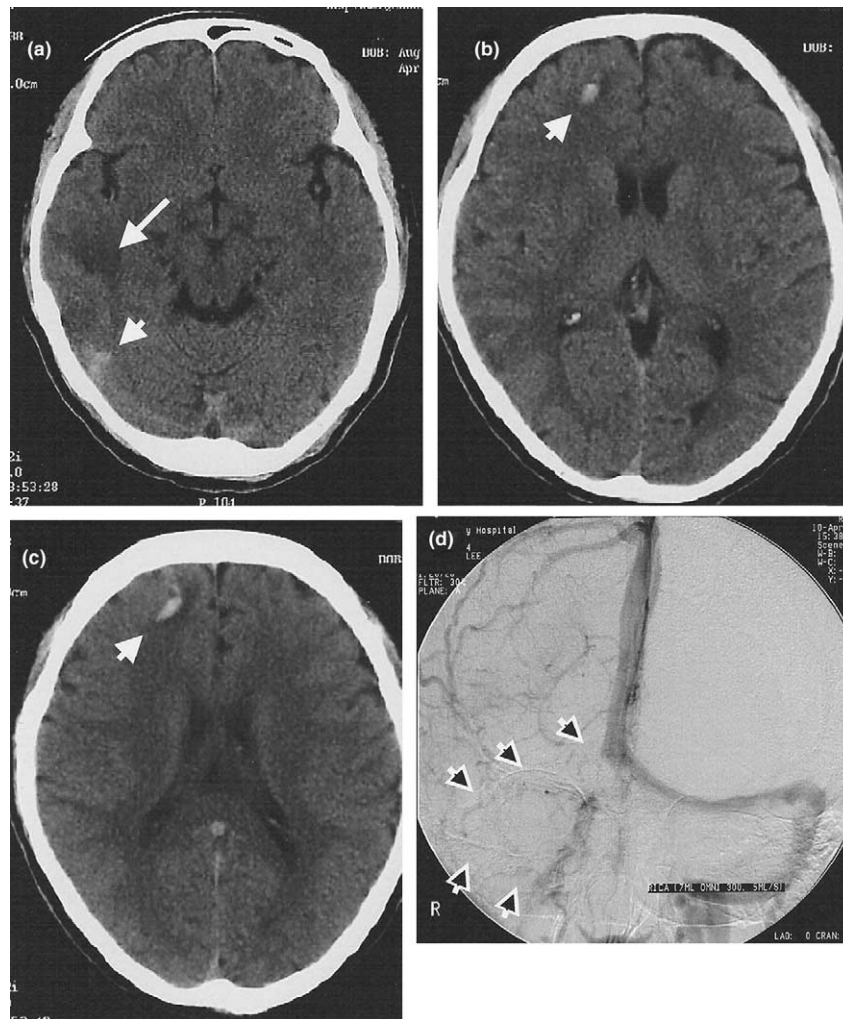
Plain computed tomography of the brain revealed acute haemorrhages (short arrows) over right anterior frontal (b, c) and posterior temporal (a) regions with adjacent oedema and right anterior temporal subcortical oedema (long arrow; a). Digital subtraction angiography showing absence of venous flow over the right transverse and sigmoid sinuses (arrows) during the venous phase to reveal cerebral venous thrombosis (d).
